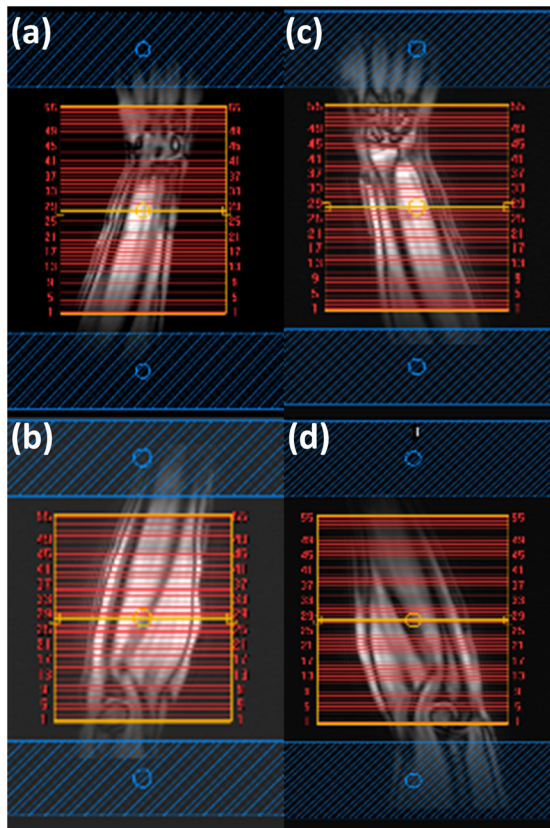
Coronal localizer of human forearm with 55 slices selected for axial MRI scanning: (a) right distal station from middle of the forearm to wrist, (b) right proximal station from elbow to middle of the forearm, (c) left distal, (d) left proximal. Two REST slabs, shown in blue, are positioned parallel to the axial slices.
